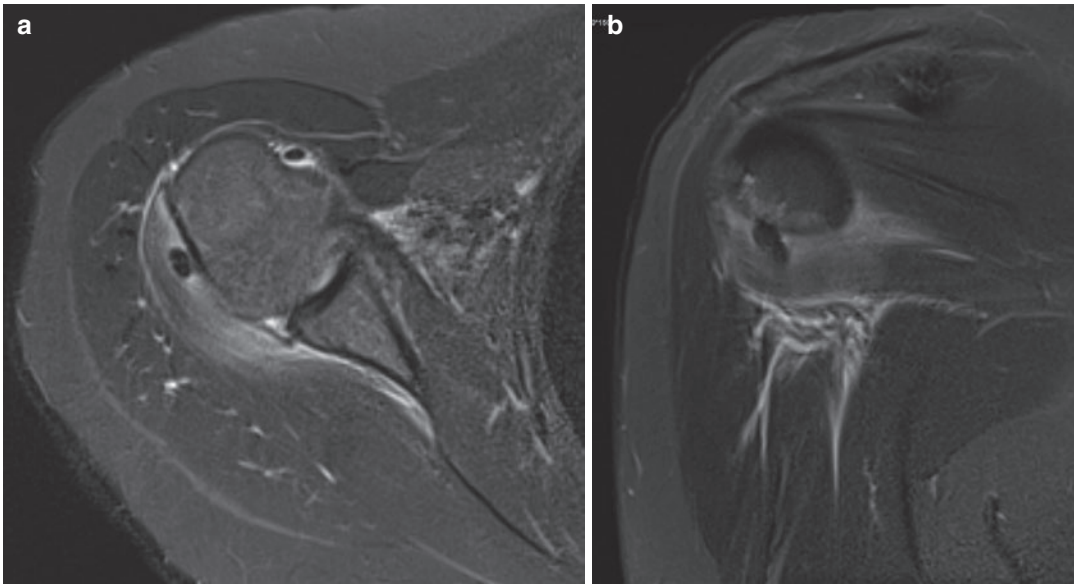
Calcific tendinosis. 40-Year-old female, weekend tennis player. Axial STIR sequence shows calcification of subscapularis tendon, extratendinous subdeltoid extension, and reactive muscle changes. Additional history was obtained by the radiologist for sudden marked pain increase. Radiograph confirmed calcific tendinosis
